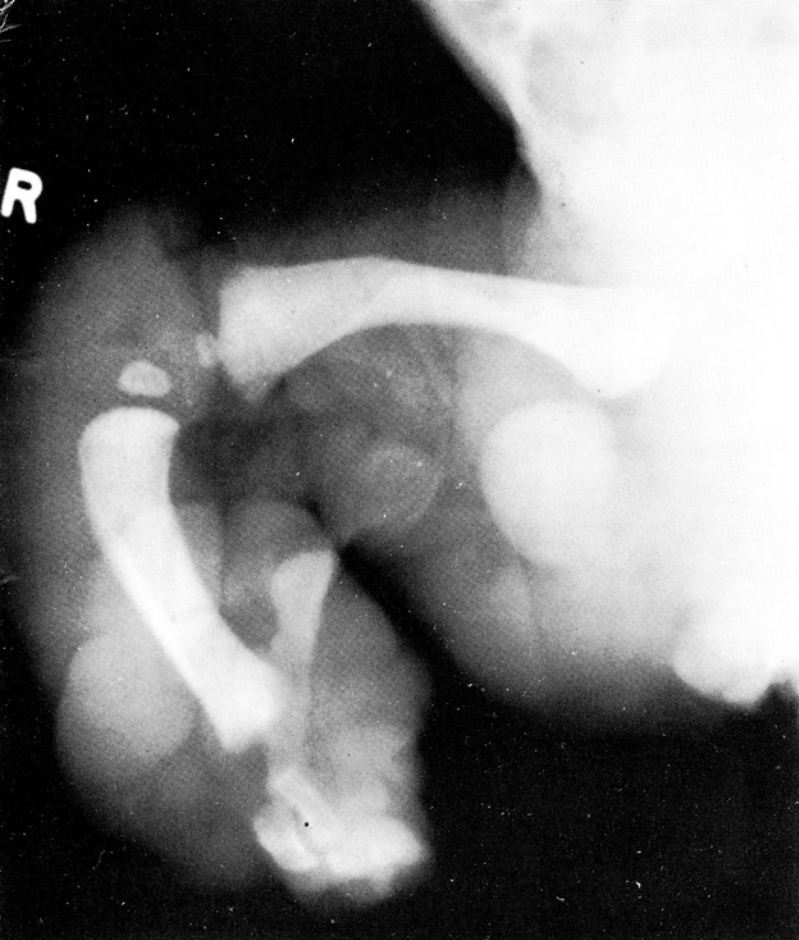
Radiographic appearance of deformed limb.
